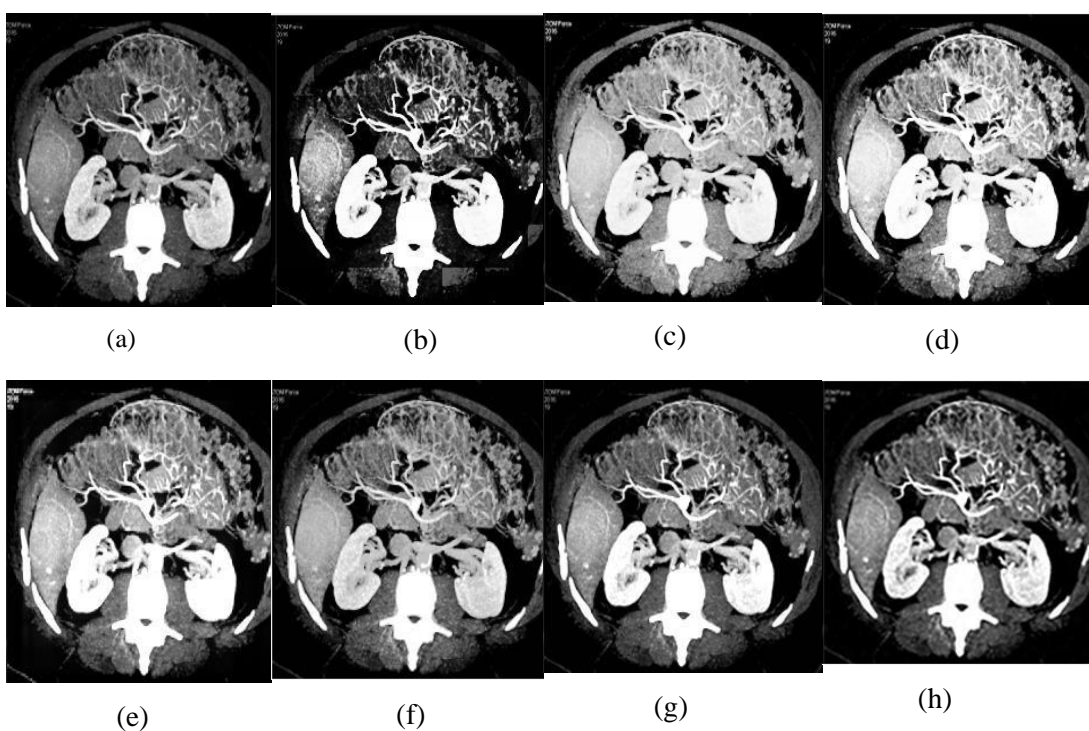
Experiment outcomes of the 'CT-7' Image (a) Original image, (b) S-curve, (c) AGC-DWT, (d) AGC-WHD, (e) GAGC-DWT, (f) EBCHE, (g) TCHE-DWT, (h) Proposed scheme
